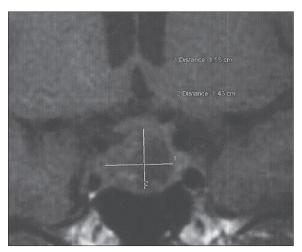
Magnetic resonance imaging showing a pituitary macroadenoma $1.2 \times 1.6 \times 1.1$ cm in the sellar region with suprasellar extension abutting of left side of optic chiasma, after second pregnancy (spontaneous abortion), after stopping bromocriptine
